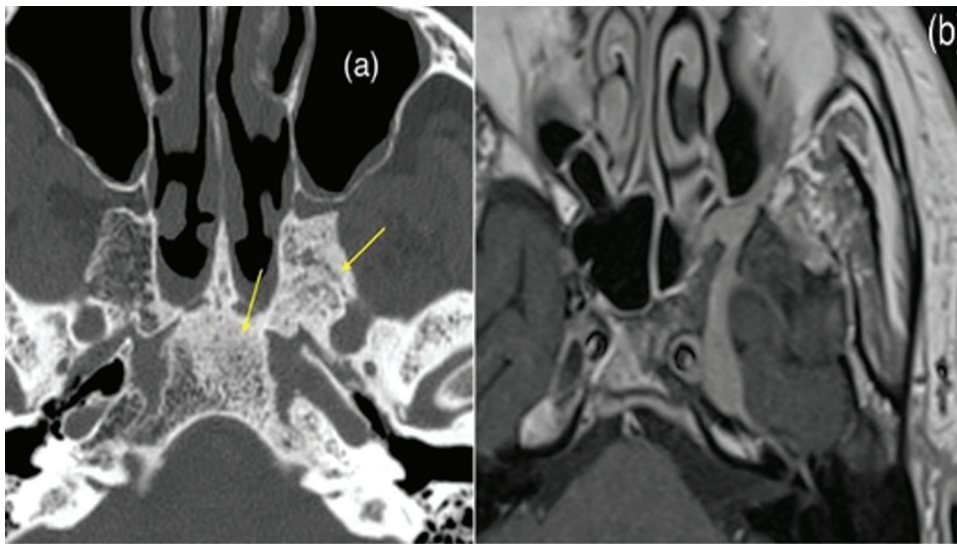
Case 1: (a) Preoperative axial CT showing the osteosclerotic infiltration of the left greater wing and pterygoid root as well as the left part of the clivus (yellow arrows). (b) Preoperative axial T1-weighted MR scans showing gadolinium-enhanced ACC at the left trigeminal ganglion and the lateral cavernous and the pterygopalatine fossa, including the divisions of the trigeminal nerve. ACC, adenoid cystic carcinoma; CT, computed tomography; MR, magnetic resonance.
